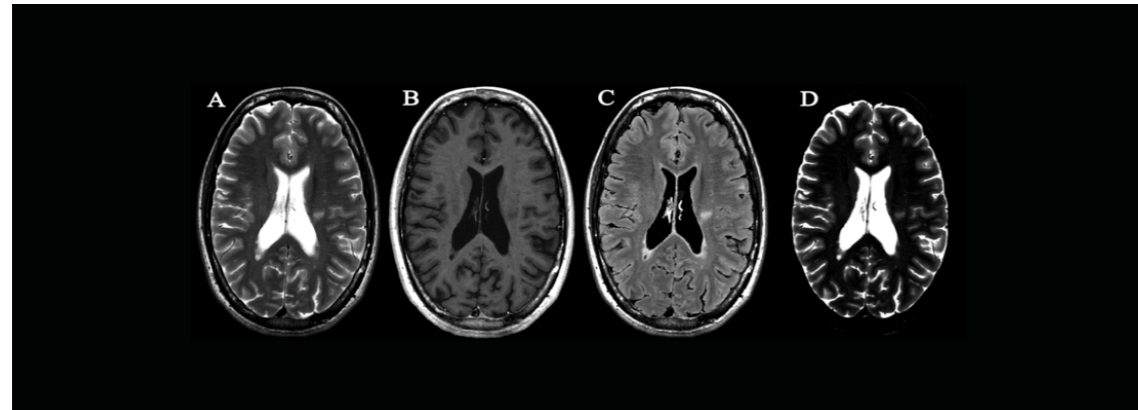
Synthetic images of an MS patient post-Gd, T2W (A), T1W (B), FLAIR (C) and STIR (D).
